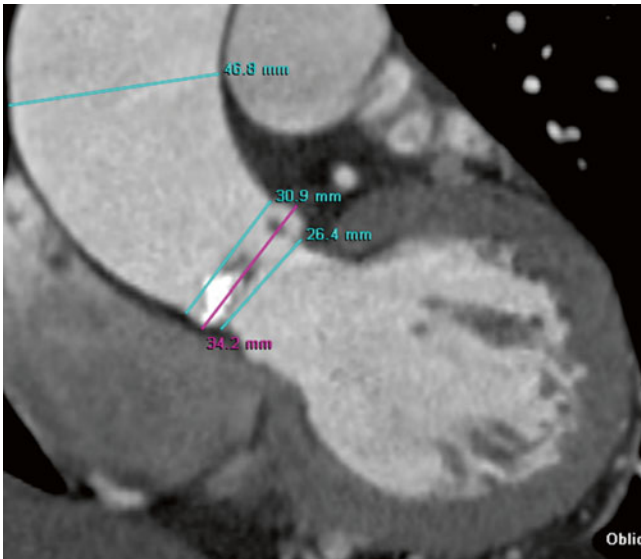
Example of measurement of ascending aorta dimensions. Oblique coronal image of CT shows the measurement of aortic root and tubular portion of the ascending thoracic aorta during mid-diastole in patient with severe BAV stenosis. BAV stenosis is related to aneurysmal dilatation of the tubular portion of the ascending aorta as like this case
